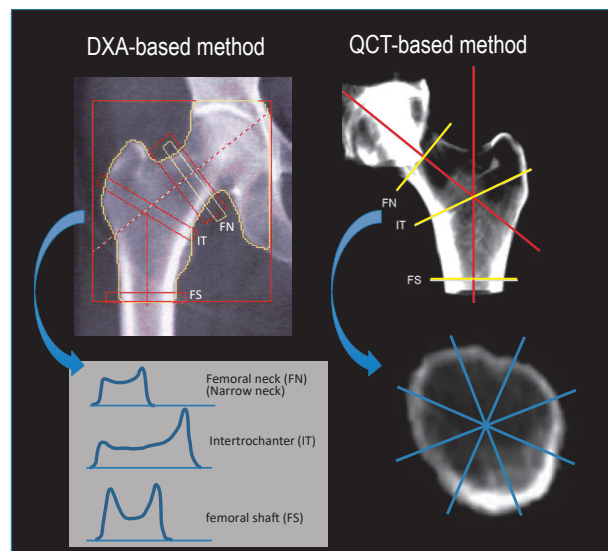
Strength analysis of the proximal femur (HSA) by CT and DXA.
